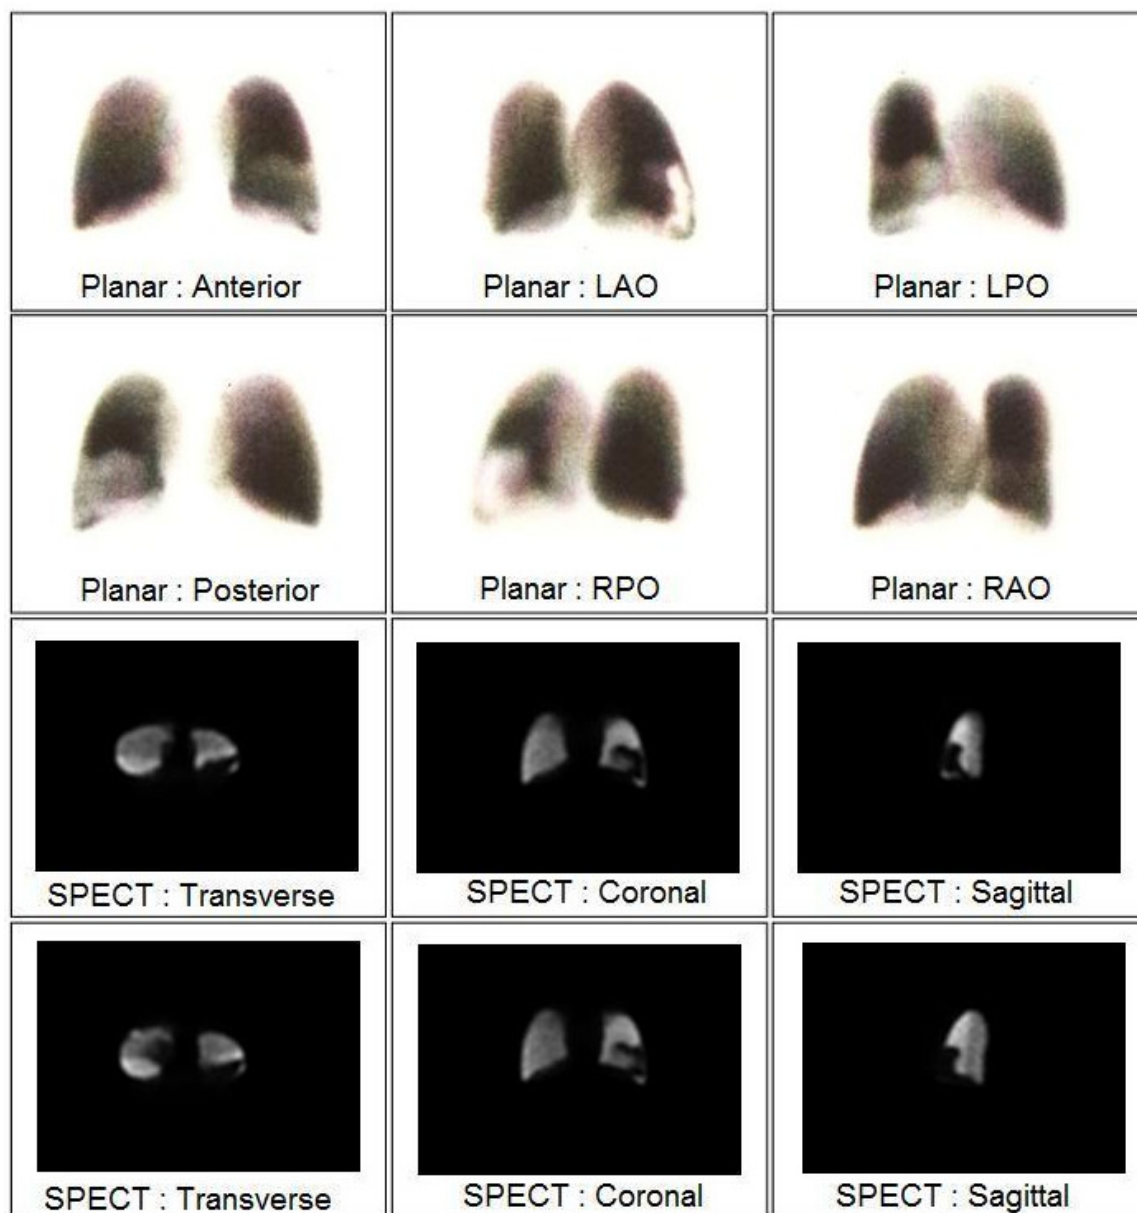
Planar and SPECT images of a perfusion defect involving the posterior basal segment of the left lower lobe.
